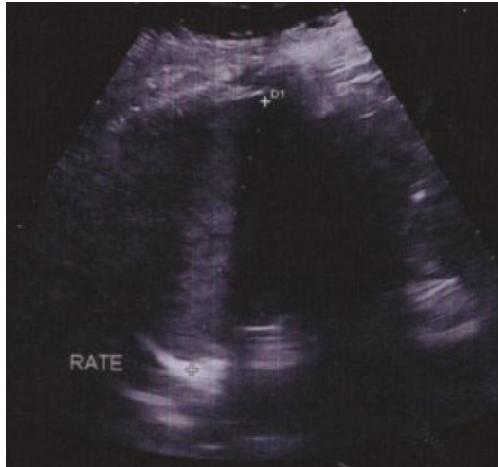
ultrasonographic appearance of a primary splenic hydatid cyst
